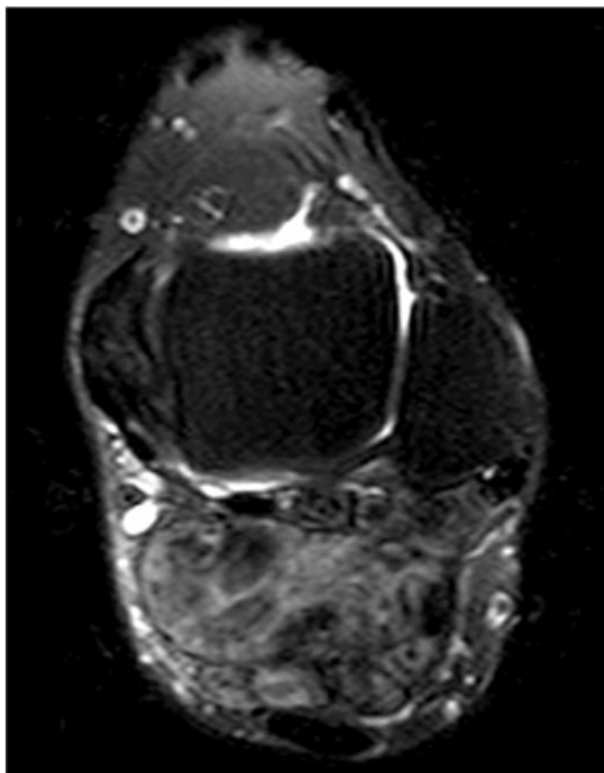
Axial scan of the lesion in T2-weighted fat saturation, showing an extensive area of haemosiderin within the lesion.
